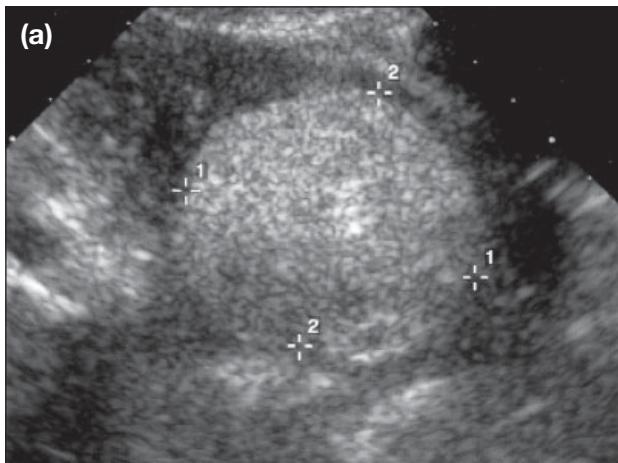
Transvaginal ultrasound examination of the uterus shows a hyperechoic mass surrounded by the hypoechoic rim of the myometrium on both (a) longitudinal; and (b) transverse scans.
